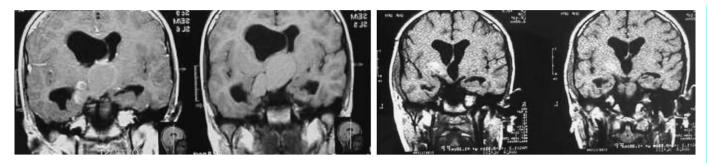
Case 2: T₁-weighted MRI before surgery and 18 months after the total resection.
